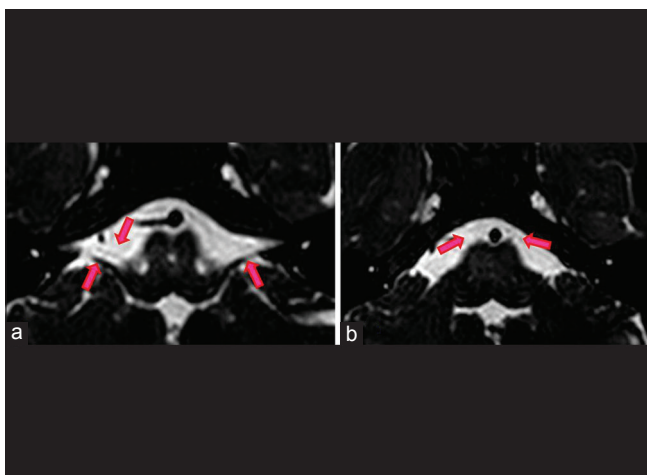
High-resolution magnetic resonance imaging images showing (a) absence of left seventh nerve (b) bilateral sixth nerve hypoplasia in Mobius syndrome
